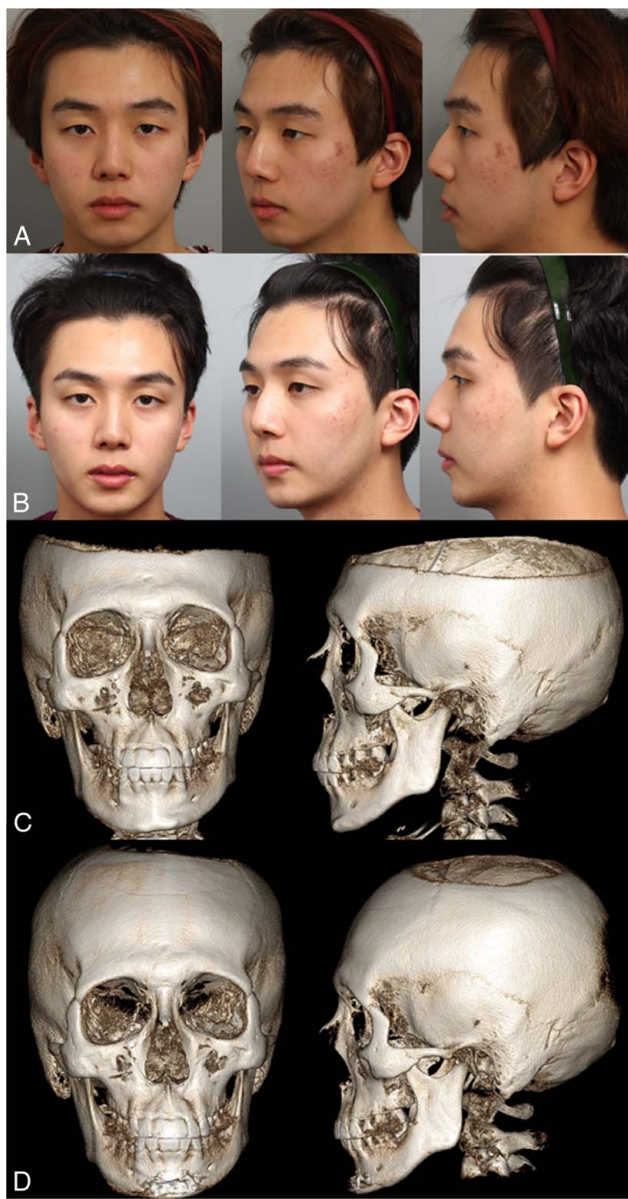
Case 2: (A) Preoperative clinical photo and (B) 6-month postoperative clinical photo. (C) Preoperative 3-dimensional computed tomography and (D) 6-month postoperative 3-dimensional computed tomography.
